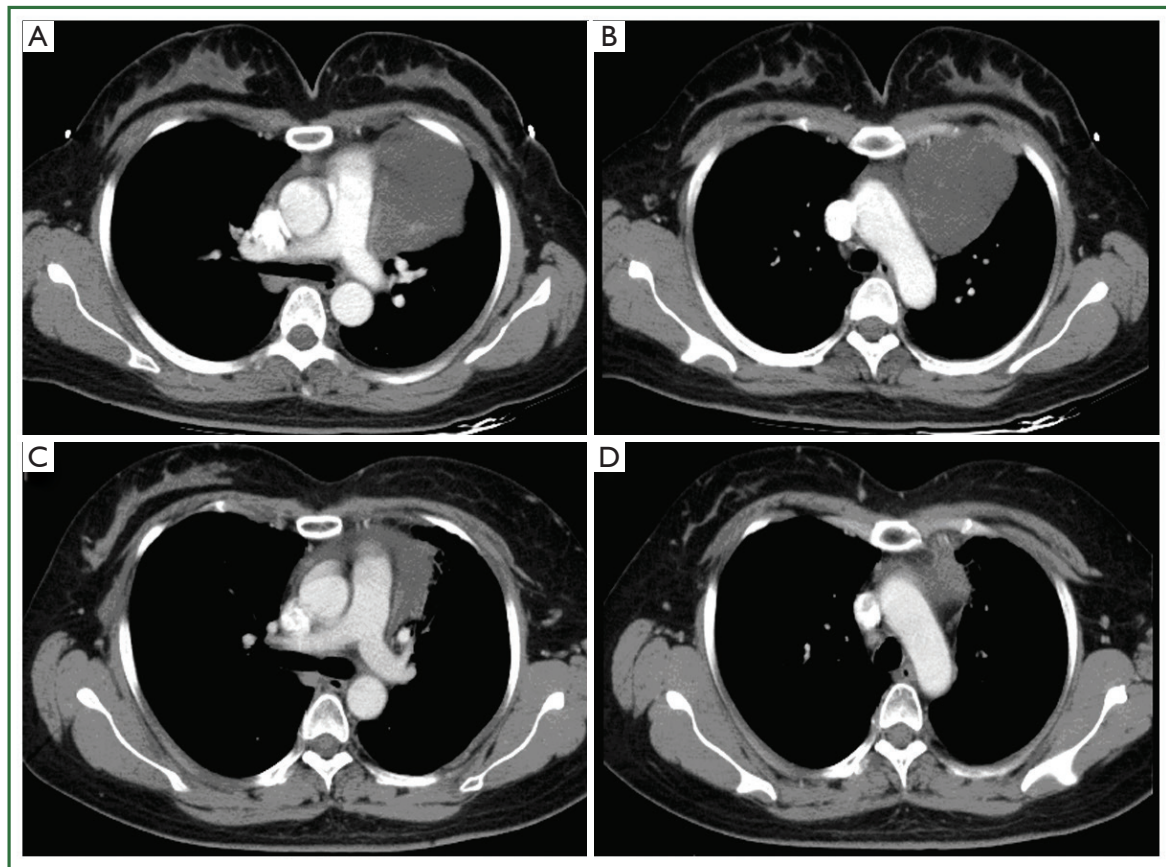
Thoracic CT revealed a primary mediastinal tumor before surgery (A, B), and a stable residual tumor (C, D) at 2-year follow-up.
